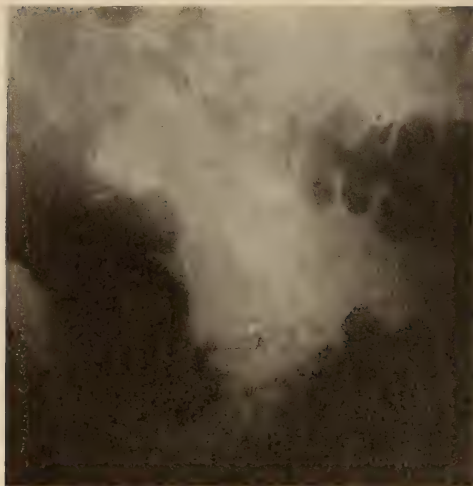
Roentgen diagnosis, chronic adhesive appendicitis. Note the filling defect and tortuosity of the appendix. Operative diagnosis confirmed.
